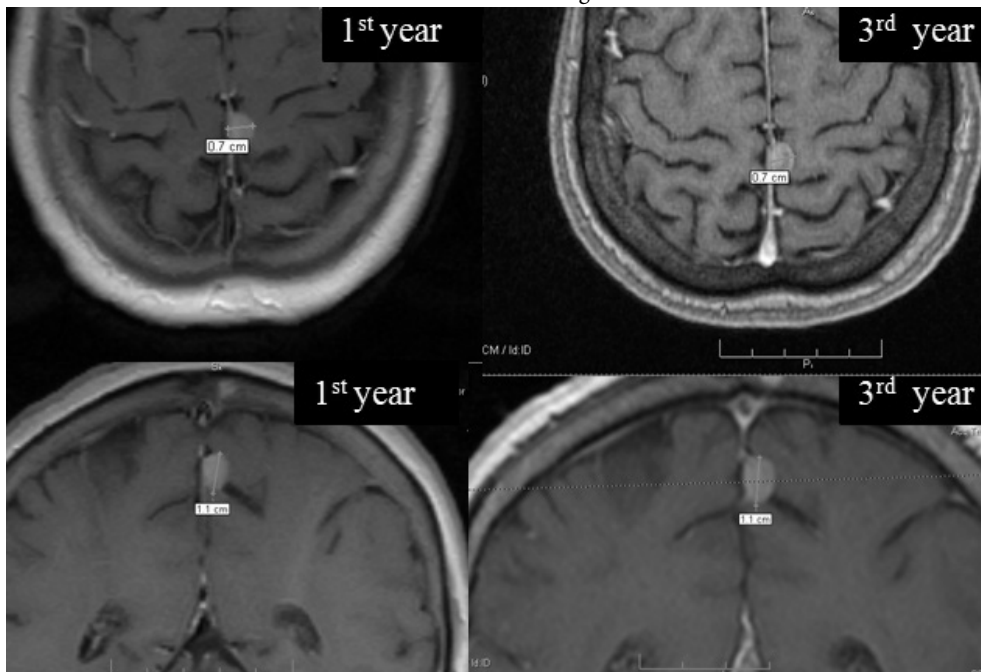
(Case 2) Axial T1-weighted images with contrast showing a left parasagittal meningioma. No increase in size of meningioma was observed at 3 years of follow-up
